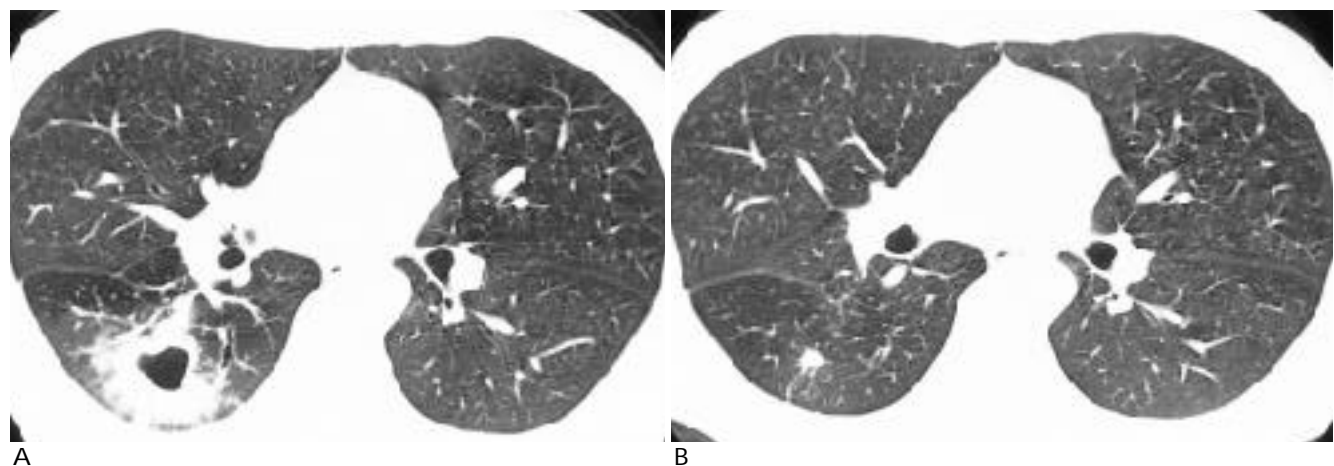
Obliteration of the cavity on the follow-up HRCT after antituberculous therapy.
